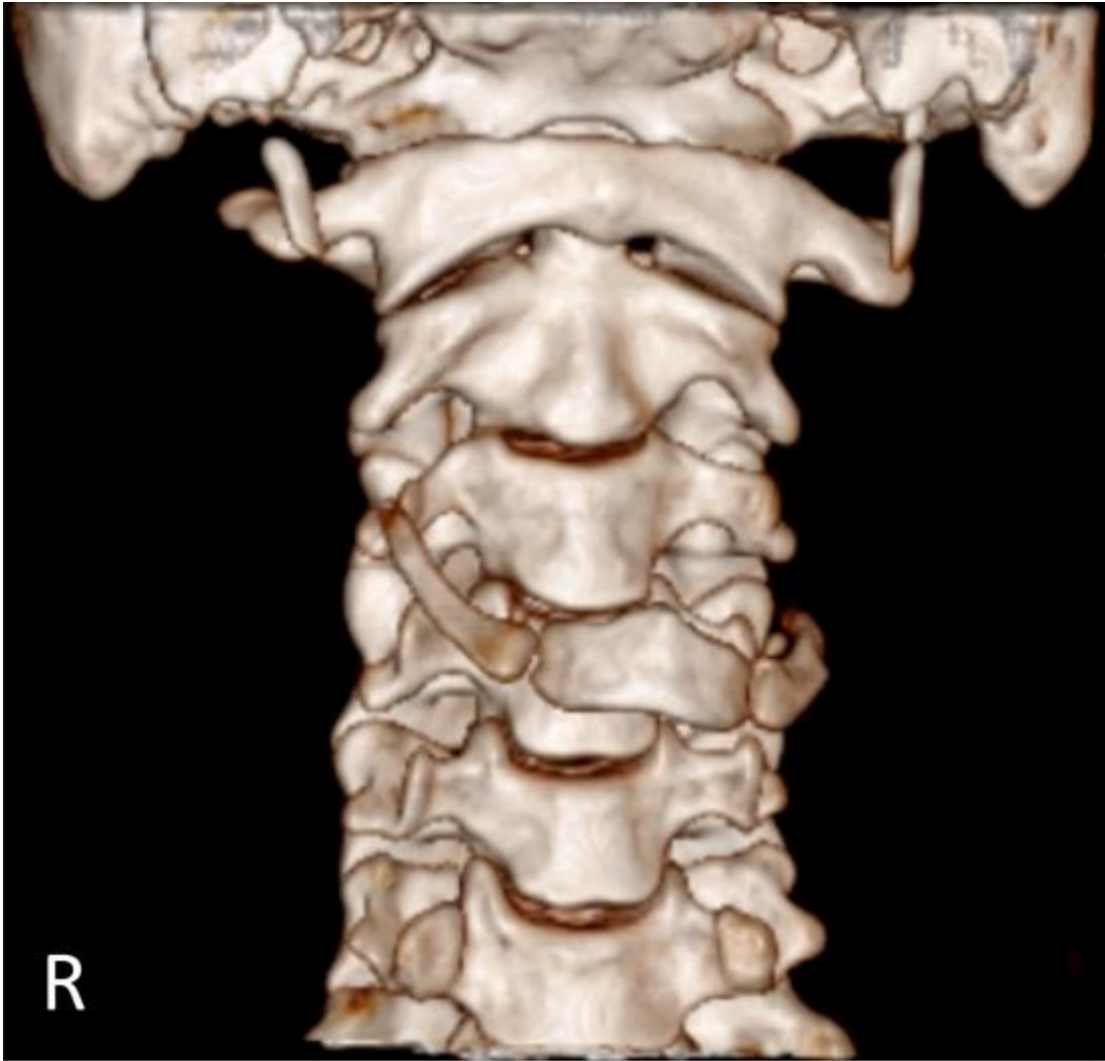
Volume Rendering Technique (VRT) reconstruction of the CT
